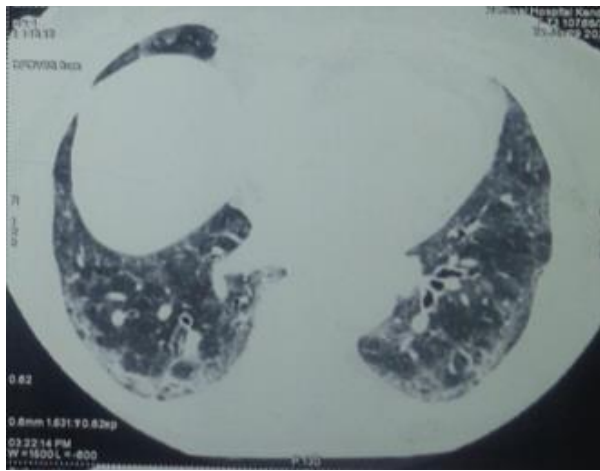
Figure (I)-Initial HRCT showing bilateral multizonal involvement with significant groundglass opacity with peripheral fibrosis and bronchiectasis changes.
